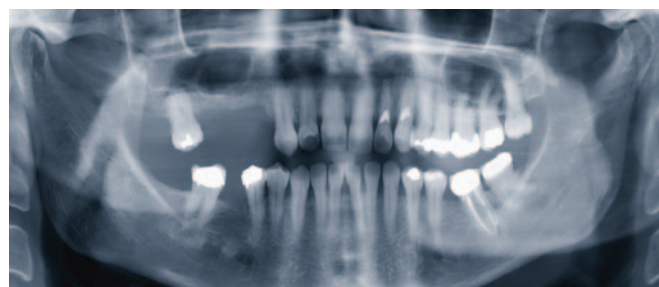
Orthopantomogram (OPG) of patient taken at initial periodontal assessment.
